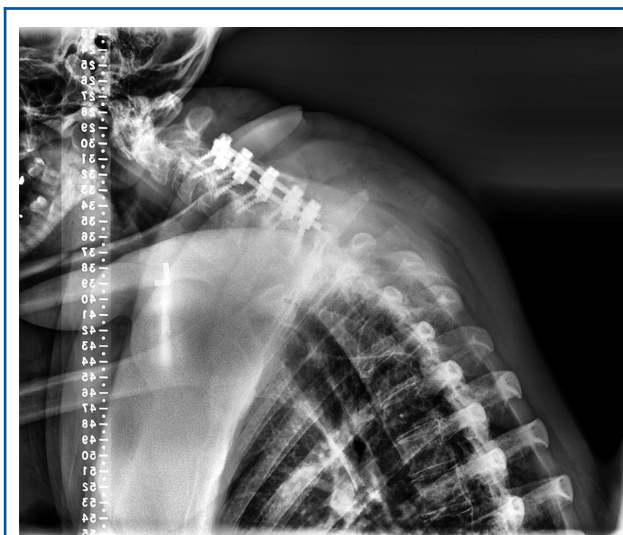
Preoperative lateral radiograph case example of a severely frail patient. The baseline CD-FI score was 0.55.
